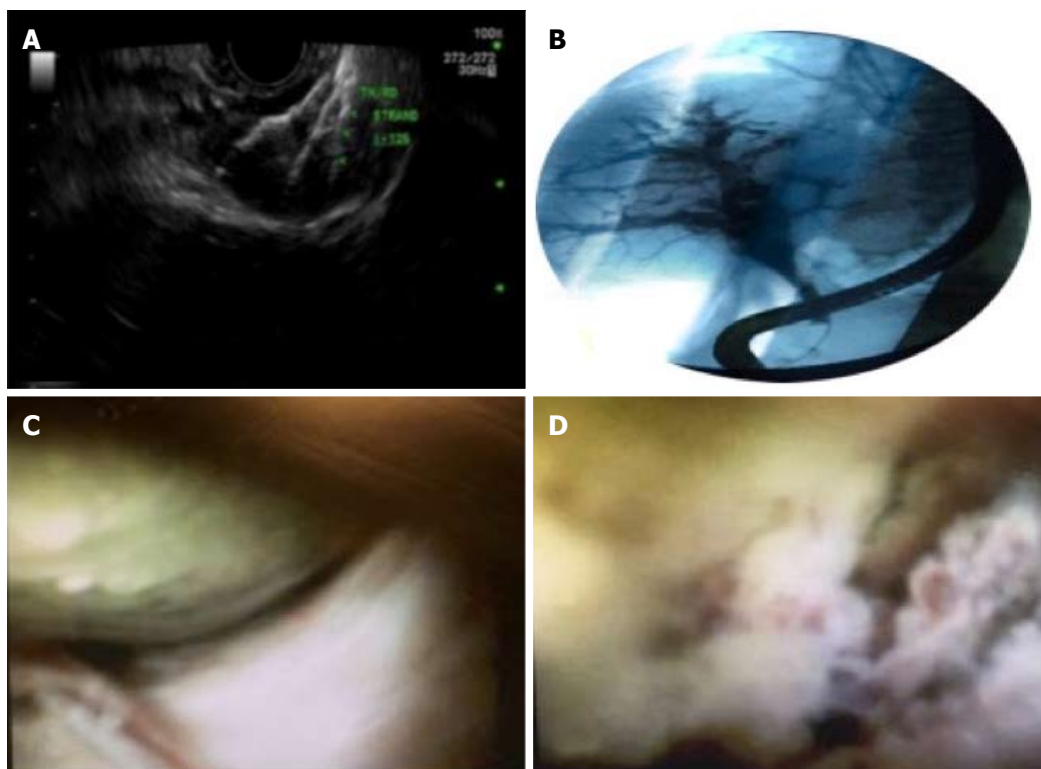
Other novel uses of endoscopic ultrasonography and cholangioscopy in hepatocellular carcinoma diagnosis and management. A: HCC EUS guided Brachytherapy: Radioactive seeds loaded and deployed with endoscopic ultrasound, similar to fiducial placement, as an alternative to transarterial chemoembolization therapy; B, C and D: Patient with choledochal cyst, found to have ectopic HCC, diagnosed with digital cholangioscopy and biopsies^[122].
